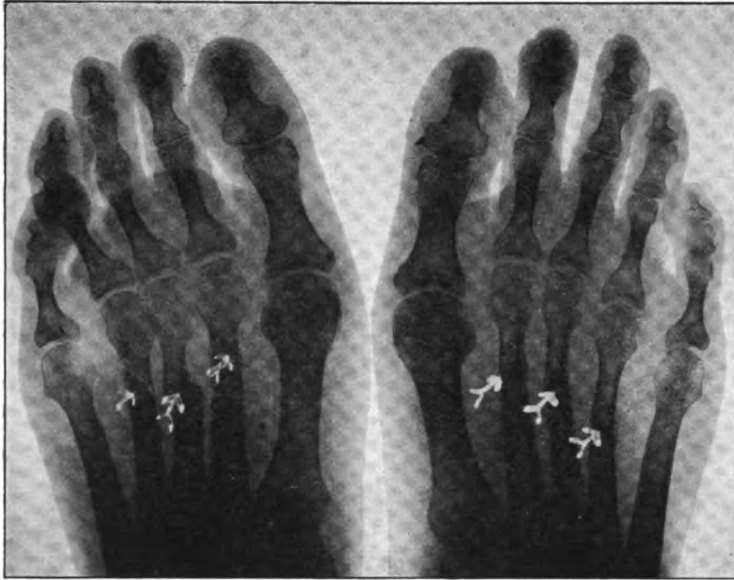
X-ray after operation. (Note the small amount of callous formation at the points of osteotomy.)
